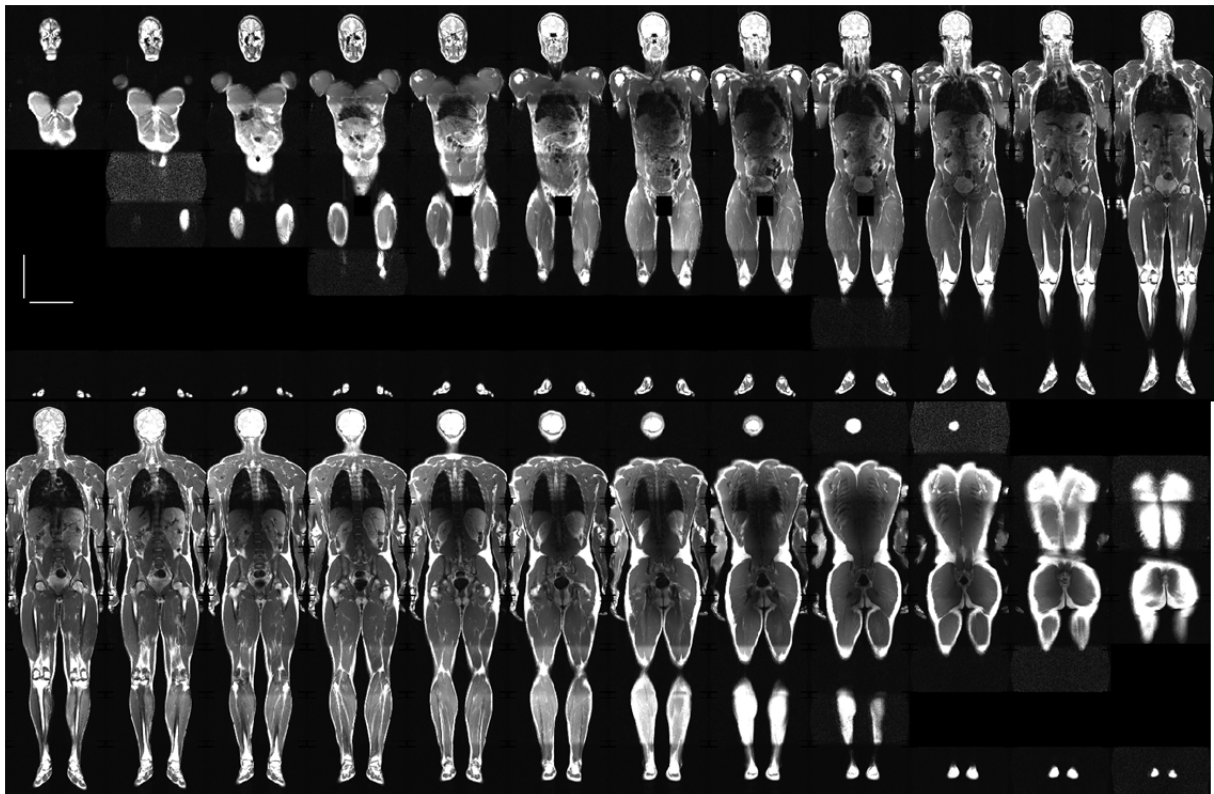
T_2 -weighted spin-echo MRI data set of an athlete. Note the excellent resolution of the surface tissue and the skeletal structure. The vertical and horizontal scale bars in the top left corner image (top left corner) indicate a length of 20cm.
